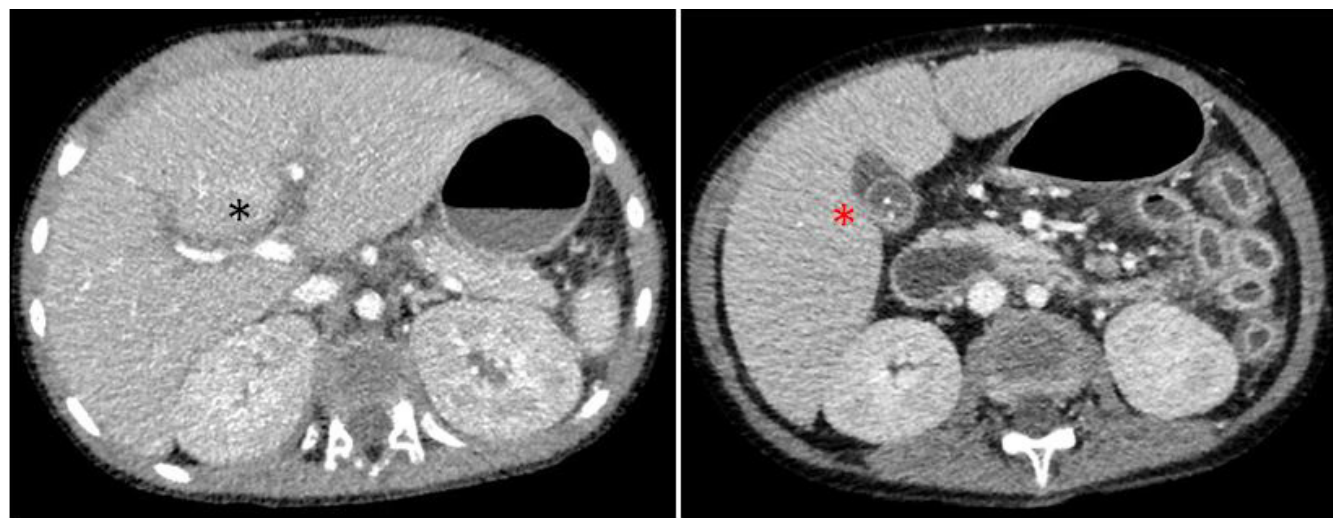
Axial contrast-enhanced CT images of the abdomen. The liver is enlarged, consistent with hepatomegaly. There is diffuse intrahepatic periportal edema, which is causing mass effect and narrowing of the portal veins (black asterisk). Gallbladder abnormalities include mural thickening and excessive enhancement, cholelithiasis, intraluminal sludge, and pericholecystic fluid (red asterisk).
